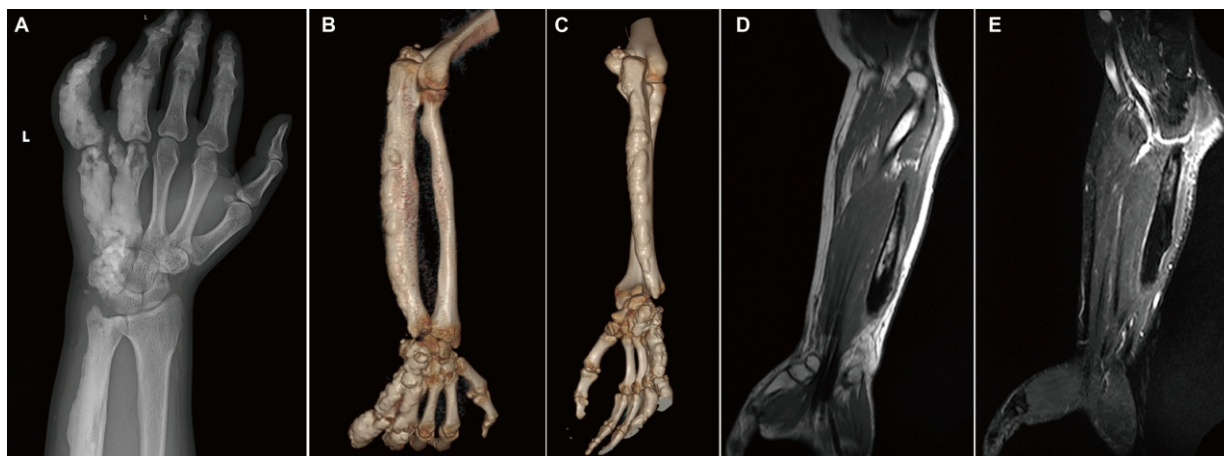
Plain radiograph, 3D CT reconstructions, and MRI of the left upper extremity. (A) Plain radiograph showing extensive undulating cortical hyperostosis with a classic "dripping candle wax" appearance along the ulnar aspect. (B, C) Three-dimensional CT reconstructions demonstrating hyperostosis extending from the medial humeral epicondyle to the 5th digit phalanges, crossing multiple joint spaces. (D) Coronal T1-weighted MRI showing the flowing hyperostosis as signal voids along the ulna and carpus. (E) Axial STIR FSE MRI revealing thickened cortices and high-signal soft tissue swelling surrounding the involved segments.
